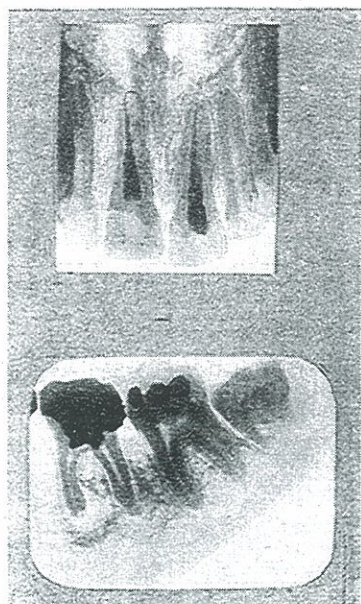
ROENTGENOGRAPHIC APPEARANCE OF TEETH, A CULTURE FROM WHICH PRODUCED THE OVARIAN AND TUBAL INFECTIONS IN THE NEXT TWO FIGURES.
